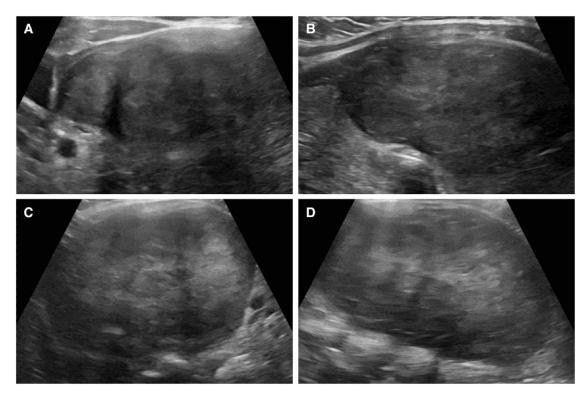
Thyroid ultrasonography showing diffuse goiter with heterogenous echotexture. No discrete nodules were observed on cine images. Rather, the entirety of both thyroid lobes appears to be replaced by a poorly defined mass. The right thyroid lobe measured 3.2 cm deep \times 5.9 cm wide \times 7.2 cm long (A = transverse, B = sagittal). The left thyroid lobe showed greater enlargement, measuring 4.2 cm deep \times 6.0 cm wide \times 11.0 cm long (C = transverse, D = sagittal). The isthmus measured 4.6 cm (not shown). No pathologically enlarged lymph nodes or calcifications were seen.
